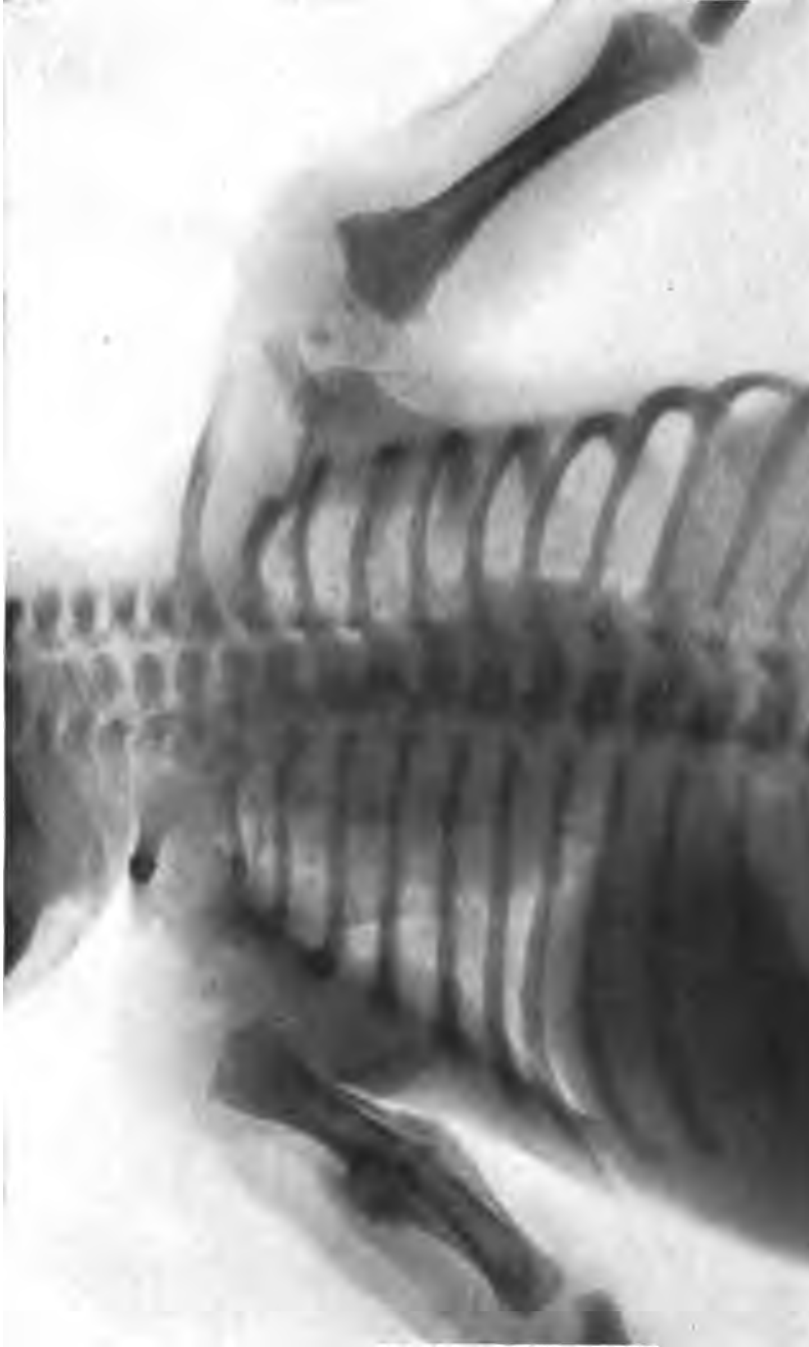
Case 2. Roentgenogram of a case of fracture of the left humerus, with dislocation of the right upper humeral epiphysis, injuries received during difficult breech extraction with arms extended above the head. At the fourth week the fracture had firmly united. There was a mass of callus in front of the point of fracture, probably representing a rent in the periosteum, while new-formed bone beneath the stripped-up periosteum, thickest at the point of fracture, shaded off towards the extremities of the humerus. The upper part of the right humeral shaft was seen surrounded by a cone-shaped deposit of similar bone. This was most marked in the region of the epiphyseal line, shading off towards the center of the bone and away from the point of injury. This is the picture produced by separation of the upper humeral epiphysis, obtained only after the process of new-bone formation is sufficiently advanced to throw a shadow in the roentgenogram. A dangling arm, with swelling about the shoulder, following a delivery which is liable to cause an epiphyseal separation aids in determining the early diagnosis, the roentgen evidence being of value only after these signs have mostly disappeared. The Wassermann reaction was negative in both mother and child.
